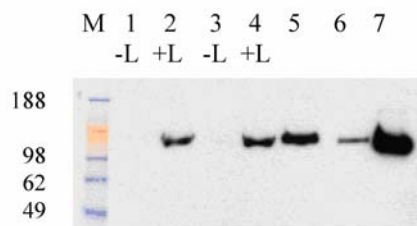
Detection of PSMA in AT3-B1 cells transfected with hPSMAs
